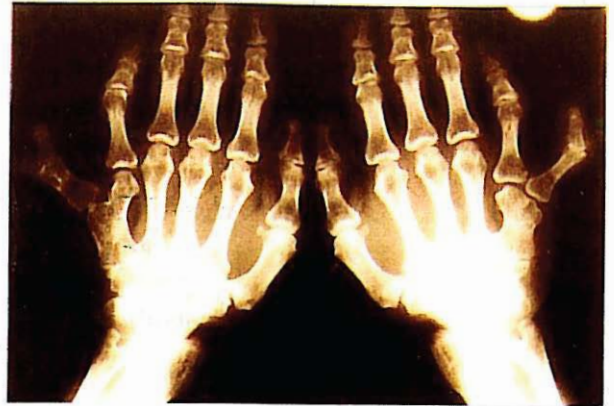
X-ray of both hands showing polydactyly and fusion of the fifth and sixth metacarpals.
